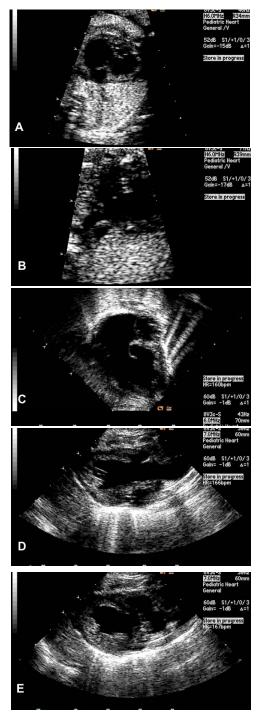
Fetal (A and B) and postanatal (C,D and E) ehocardiographic views showing the double-inlet LV with both atria connected to the same ventricle with left atrioventricular valve atresia. The modified parasternal views show the relationship of the great arteries: the aorta originates from the posterior LV and the pulmonary artery comes off from a rudimentary anterior outlet chamber.
